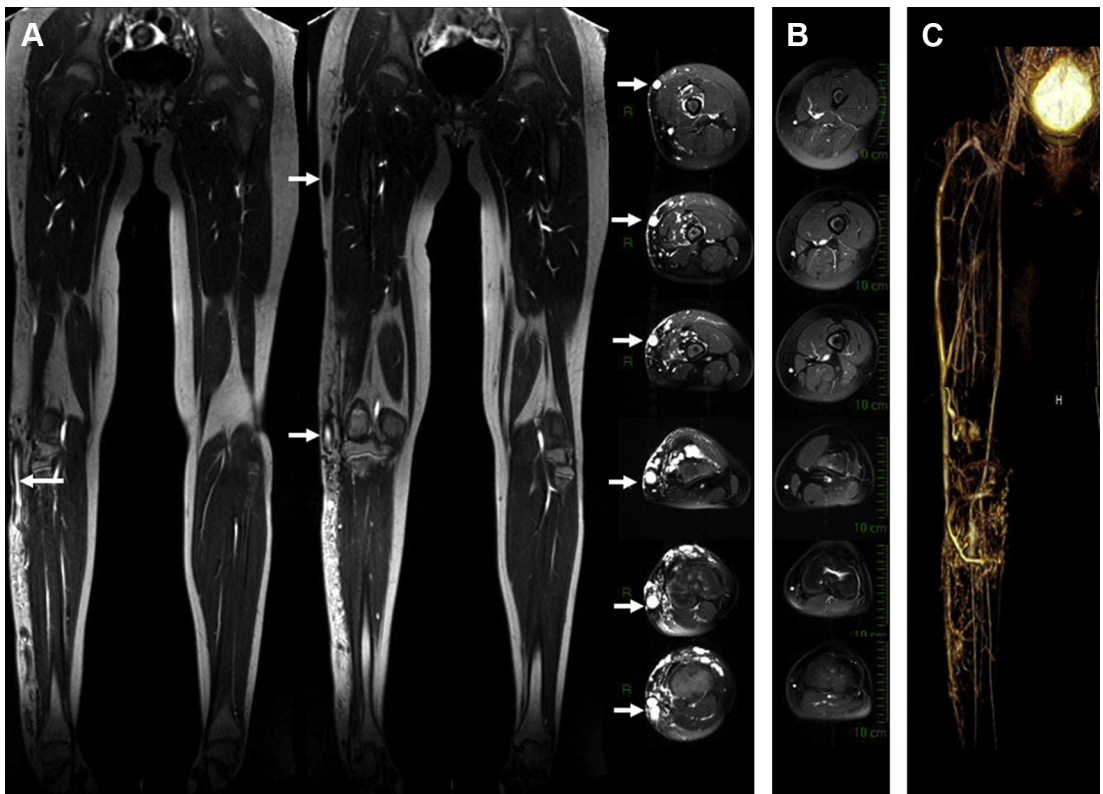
Parkes Weber syndrome. WB MR imaging coronal T1-weighted images (A) and axial STIR images (B) showing the enlargement of the right inferior limb caused principally by arteriovenous malformation (white arrows). Note on angio-MR imaging (C) the arteriovenous malformation without an important fistula component.
